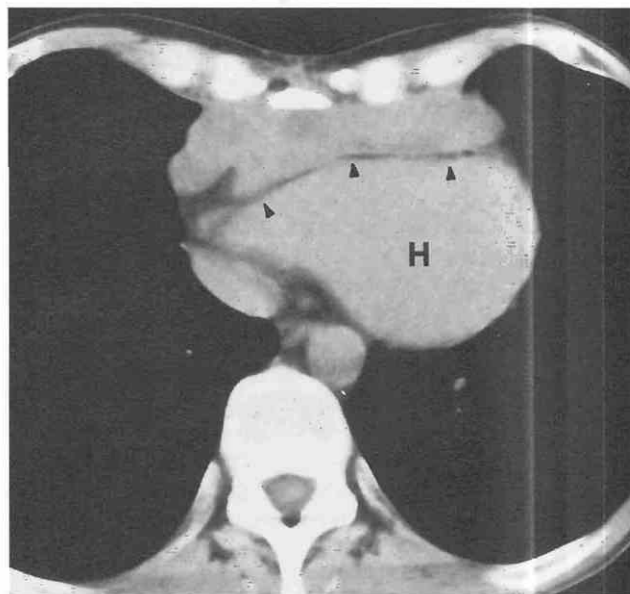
Primary mediastinal sarcoma. CT shows large, lobular, heterogeneous anterior mediastinal mass. The fat plane (arrowheads) between the mass and the adjacent compressed heart (H) is preserved.
